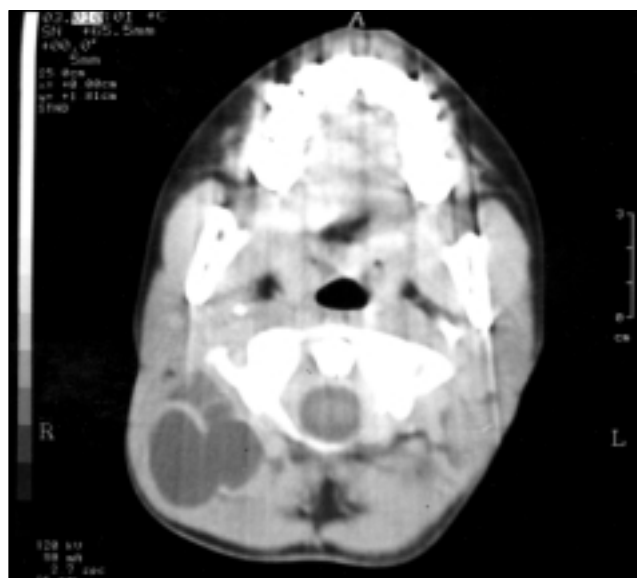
The computed tomography scanning with contrast infusion showed a well-circumscribed, lobulated, showing septations cystic mass.
